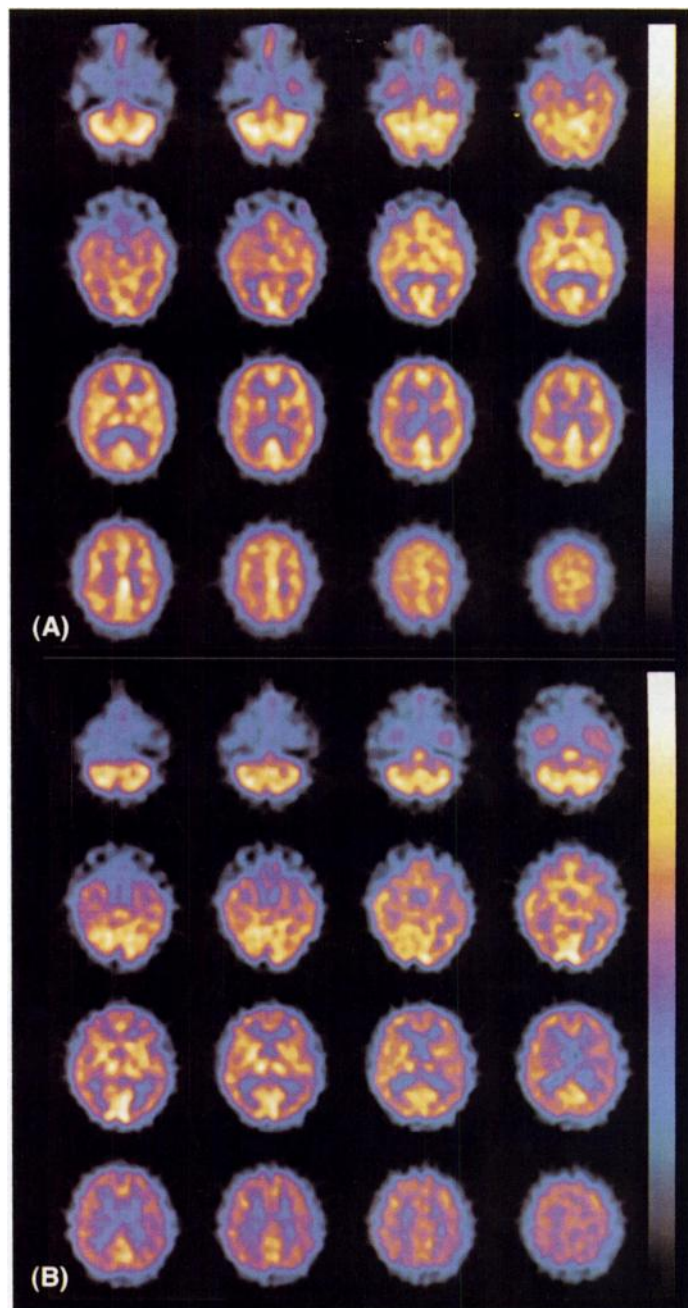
Transaxial slices (SPECT) in two patients with TBE. (A) Woman (32 yr) examined 44 days after onset of mild meningoencephalitis with paralysis of urinary bladder. Normal rCBF. (B) Man (60 yr), with dysesthesia, examined 43 days after onset of moderate encephalitis. Decreased rCBF (flow rate 2) with generally patchy pattern bilateral.
